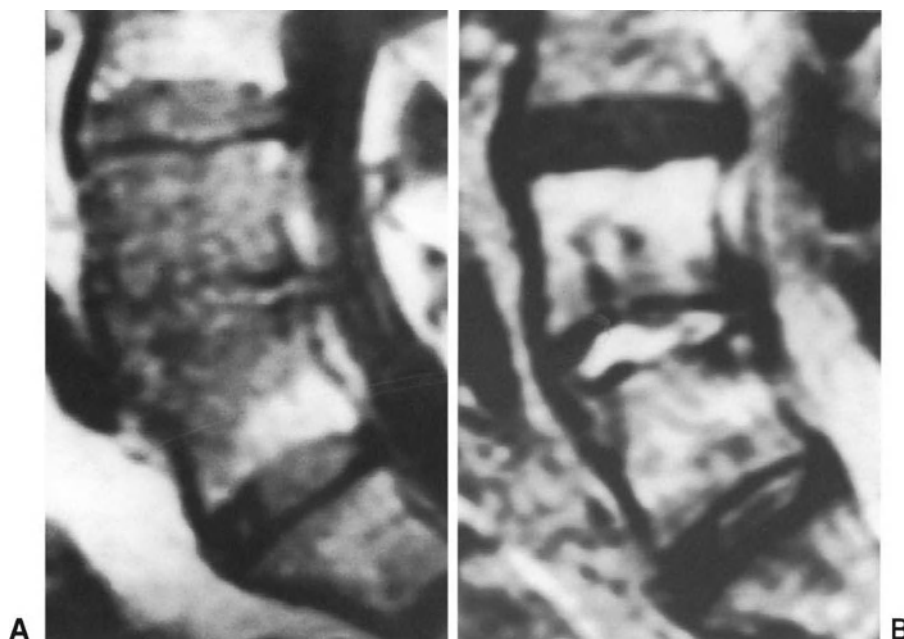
MRI scans in a patient with postoperative spondylodiscitis at L4-L5 level. (A) Spin-echo T1-weighted sagittal image showing a decreased signal intensity of the L4-L5 disc and most of the adjacent vertebral bodies. Note that the disc is no longer distinguishable from the L4 and L5 vertebral bodies. (B) Spin-echo T2-weighted sagittal image demonstrating an increase in signal intensity of the L4-L5 disc.
